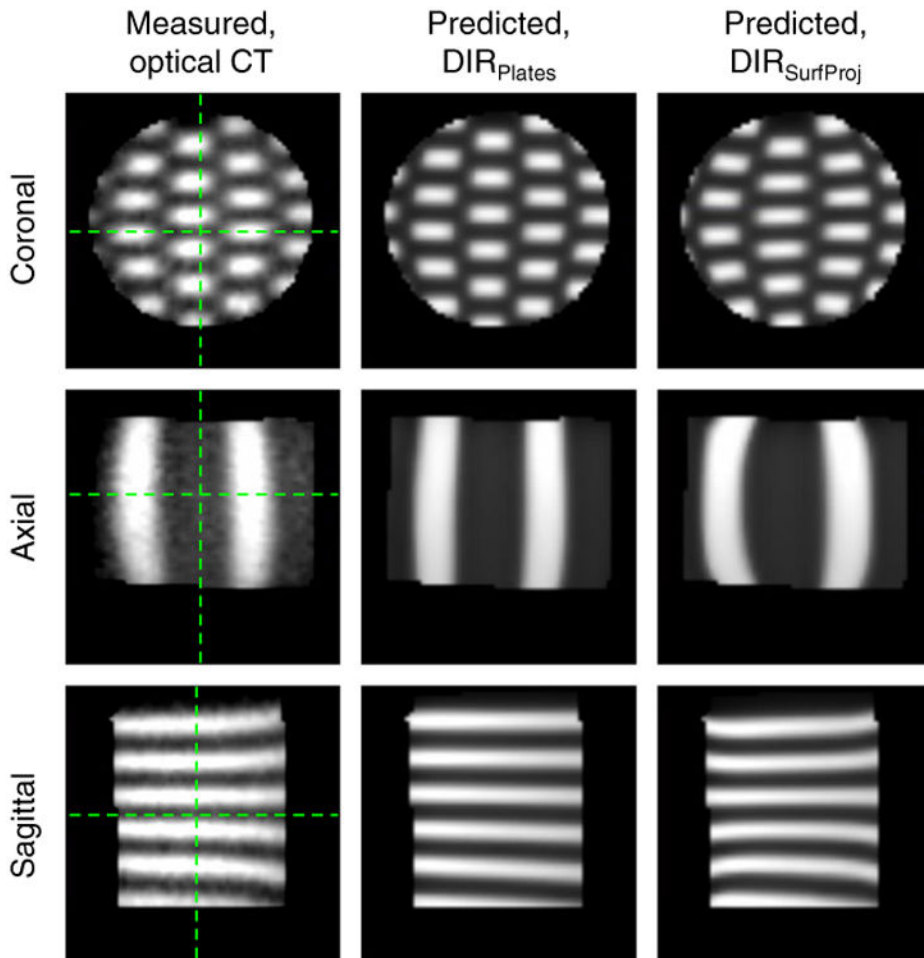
The deformed dose distributions in the dosimeter's uncompressed geometry measured with optical computed tomography (CT) or predicted by use of either deformable image registration model (DIR_{SurfProj} or DIR_{Plates}). Green lines indicate the orientations for corresponding planes. (See Methods for complete description of DIR models). (Color version available online at www.practicalradonc.org).
